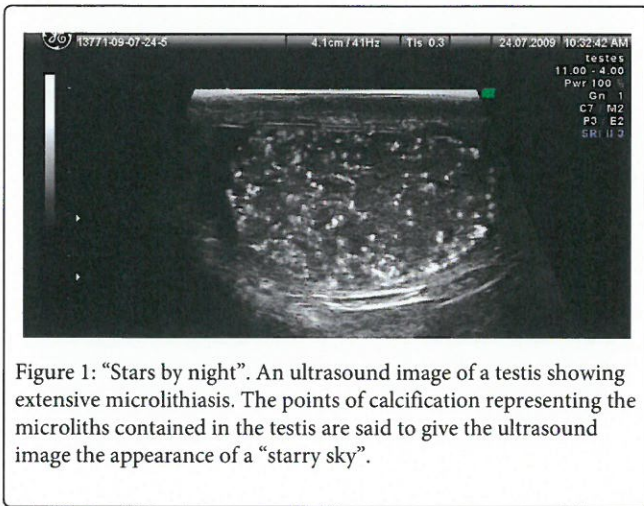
"Stars by night". An ultrasound image of a testis showing extensive microlithiasis. The points of calcification representing the microliths contained in the testis are said to give the ultrasound image the appearance of a "starry sky".
